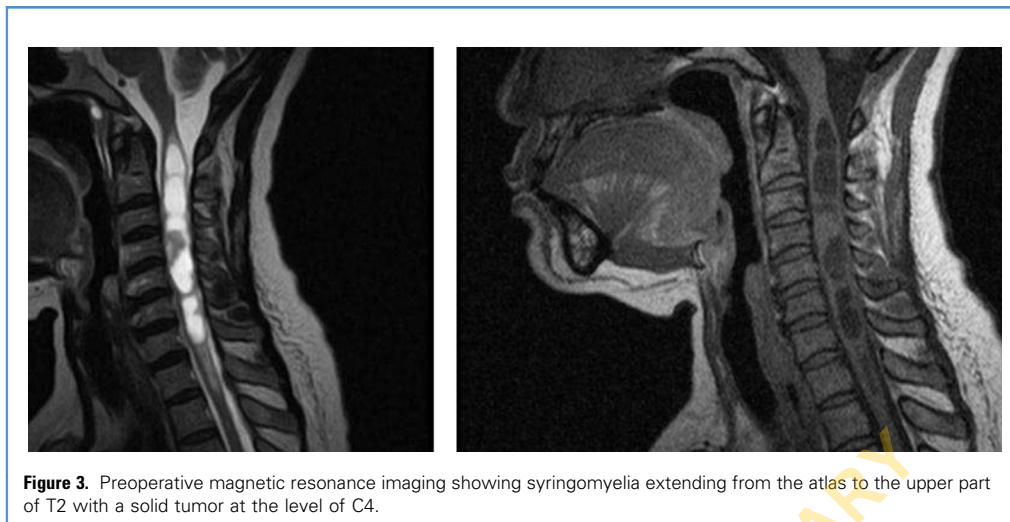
Preoperative magnetic resonance imaging showing syringomyelia extending from the atlas to the upper part of T2 with a solid tumor at the level of C4.
